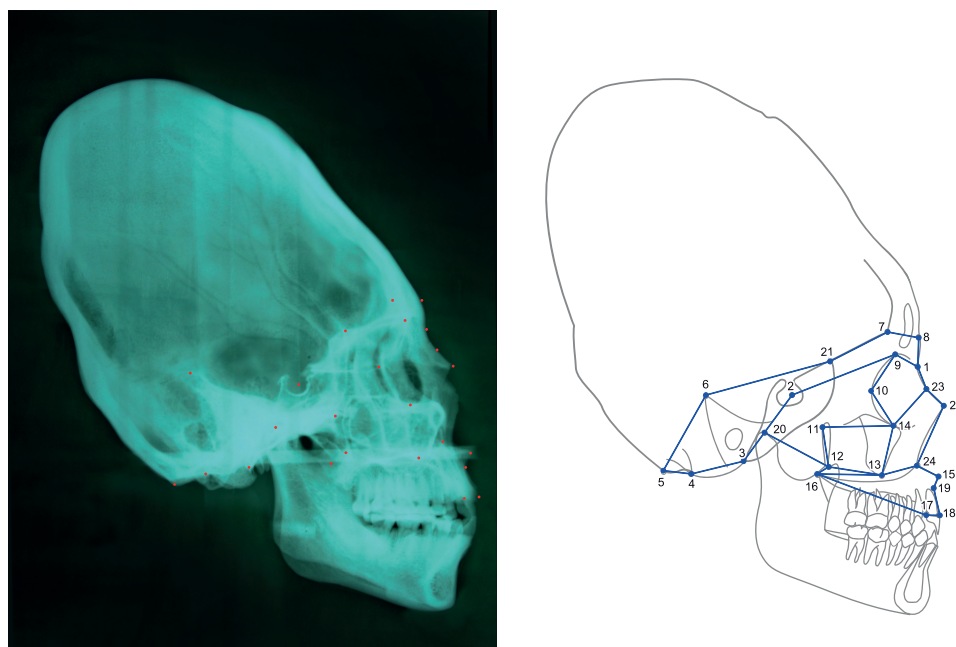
Left: X-ray of a circumferentially deformed skull with the landmarks. Right: wire frame and landmarks used in the analyses. See Table 1 for a definition of the landmark positions.
